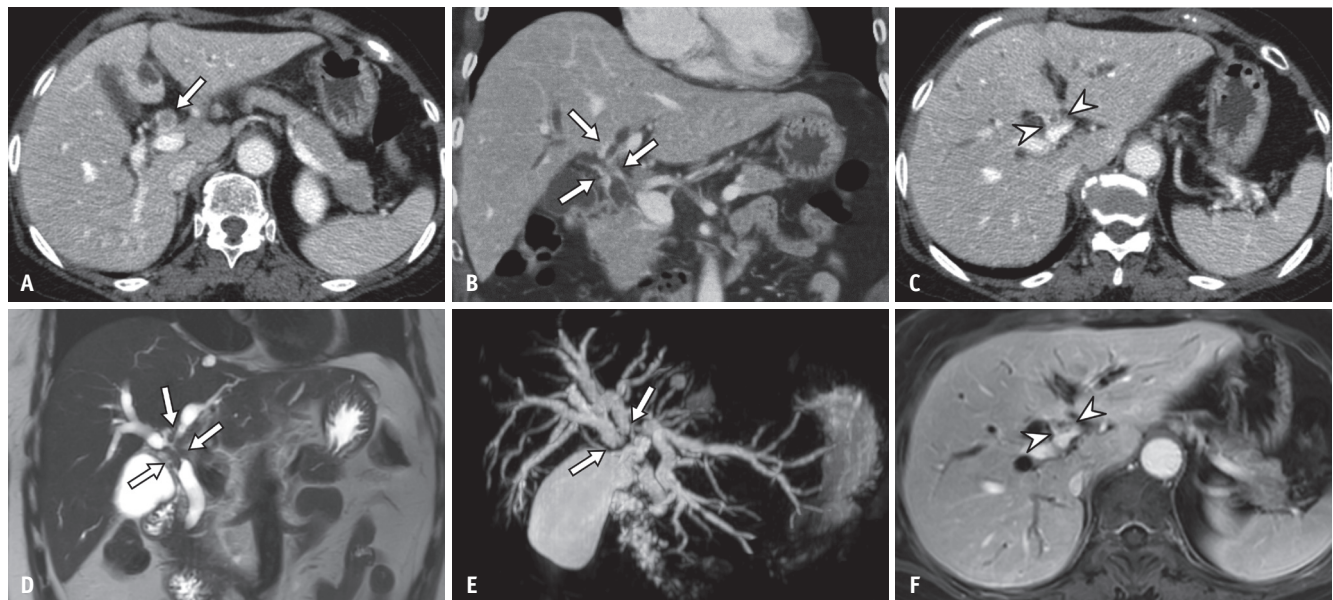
A 69-year-old female patient with surgically confirmed perihilar cholangiocarcinoma with pathologic staging of T4N2. Axial (A, C) and coronal (B) portal venous phase CT images reveal wall thickening and enhancement of the common hepatic duct and left hepatic duct (A, B, arrows) abutting the left portal vein (C, arrowheads). On CT, the tumor was classified as Bismuth type II or IIIb with probable resectability. On coronal T2-weighted (D) and MRCP (E) images of CE-MRI with MRCP, ductal wall thickening is seen in the common hepatic duct, left hepatic duct (D, arrows), and right secondary confluence separation (E, arrows). The axial portal venous phase image (F) shows luminal narrowing of the left portal vein (arrowheads). The reviewers assessed this case as “probably” unresectable with Bismuth type IV classification on MRI and combined review of CECT and CE-MRI with MRCP. The patient underwent an extended right hemihepatectomy, and the tumor involved the surgical margin at the left secondary confluence and bile duct radial margin. CT = computed tomography, MRCP = magnetic resonance cholangiopancreatography, CE-MRI = contrast-enhanced magnetic resonance imaging, MRI = magnetic resonance imaging, CECT = contrast-enhanced computed tomography
